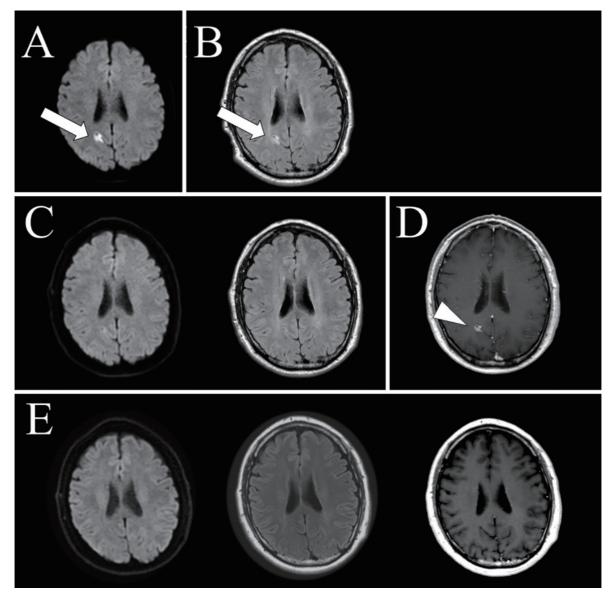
Serial MRI scans. On admission, diffusion-weighted imaging (DWI, A) and fluid-attenuated inversion recovery (FLAIR, B) show a hyperintense signal near the right parieto-occipital sulcus (arrow). Seven days after onset, the lesion visible on DWI and FLAIR has disappeared (C) but is detectable on gadolinium-enhanced T1-weighted MRI (T1-WI, D, arrowhead). A follow-up MRI 2 months after onset shows no definitive lesion, even on T1-WI with gadolinium enhancement (E).
